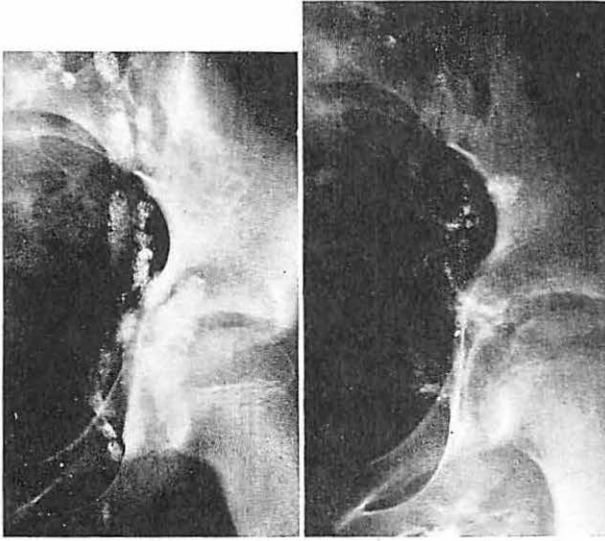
Ewing's sarcoma relapse*, detected on surveillance follow-up in a 9 year old girl; (Left) The lymphogram was interpreted as being negative. (Right) Three months later, a repeat radiograph showed interval marked enlargement of many external iliac lymph nodes, interpreted as representing relapse.
